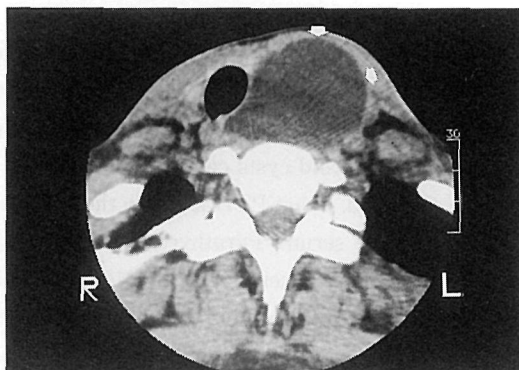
Computed tomographic scan at the level of the neck demonstrating a cystic mass (arrows) adjacent to the left thyroid gland.
